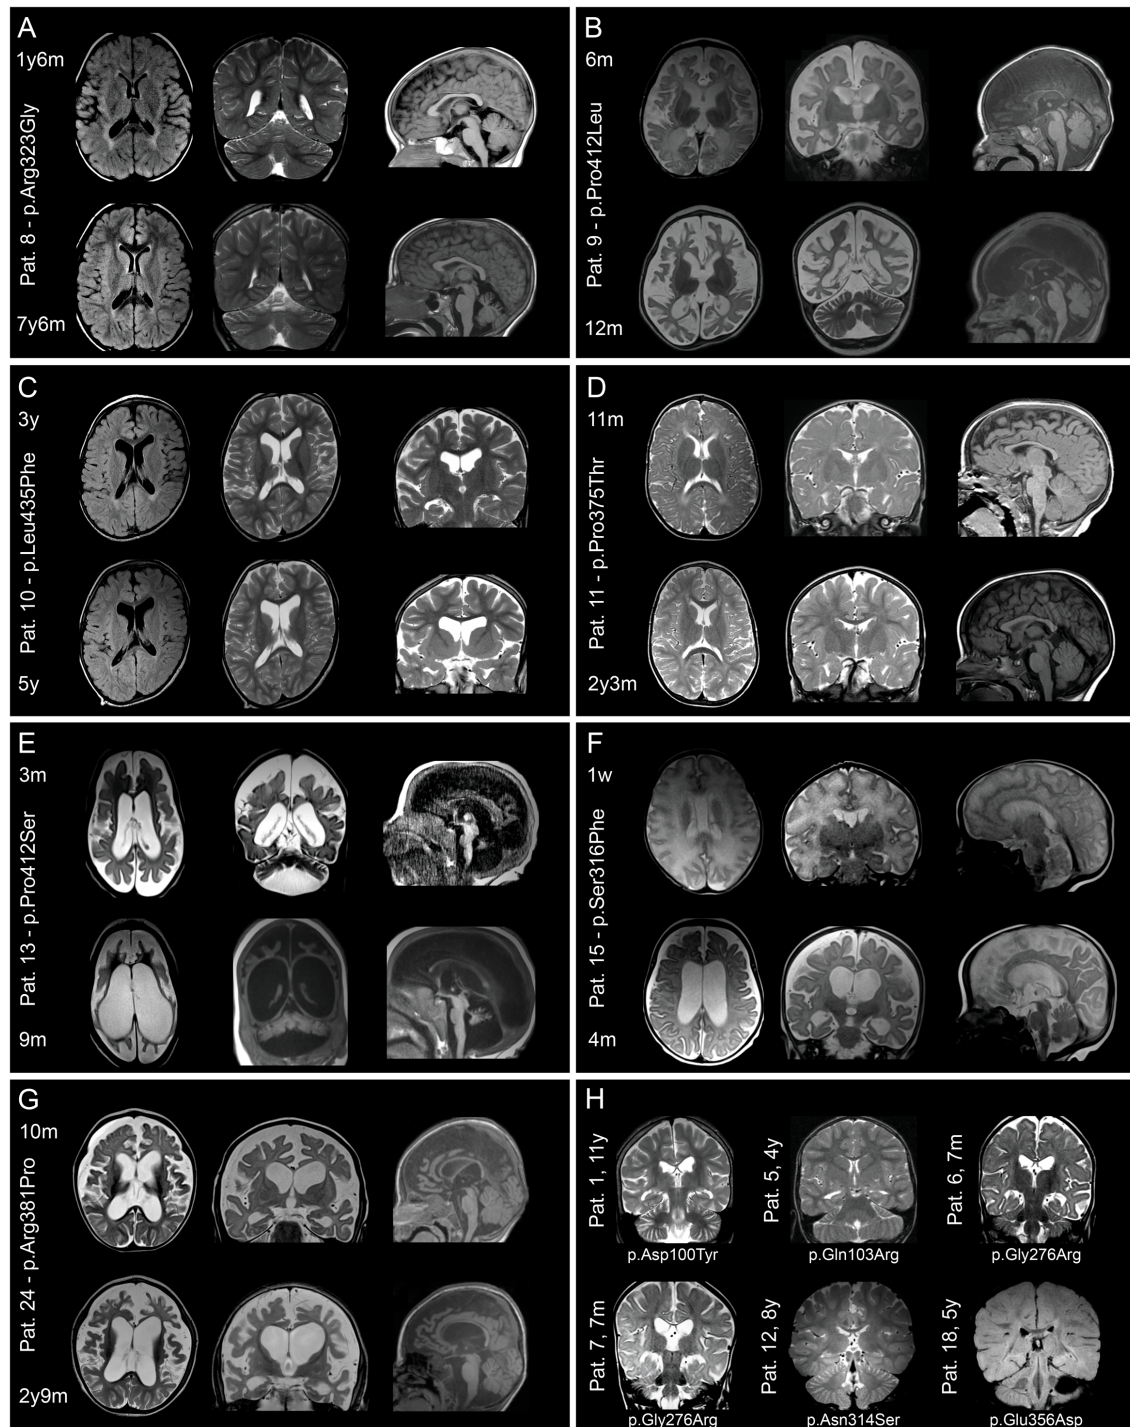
Brain MRI in patients with *ATP6V1A* pathogenic variants. MRIs of patients who were imaged at least twice are shown in A-G. Images were taken from the initial and last follow-up investigations at 1.5 to 3T and include
